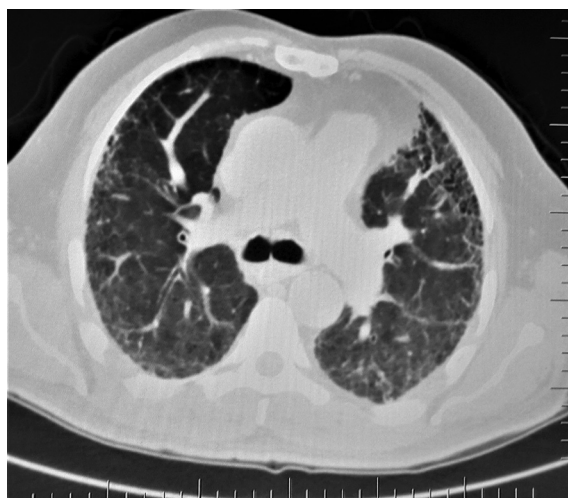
CT scan of the same patient on the 7th day after admission of the ICU.
